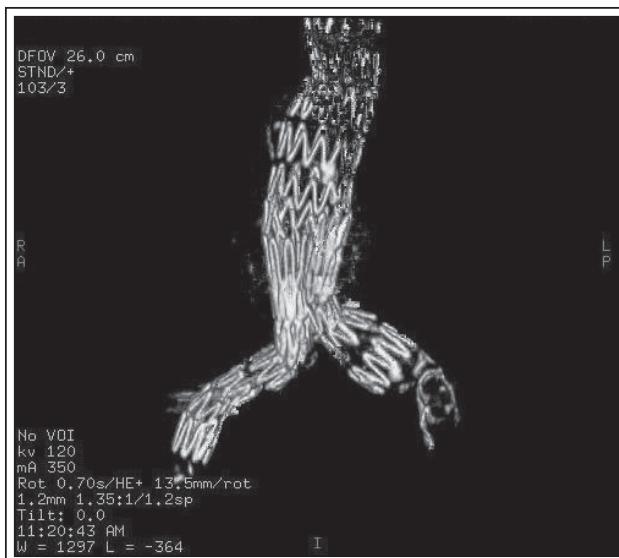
Three dimensional CT coronal reconstruction of endograft at 3 years.
